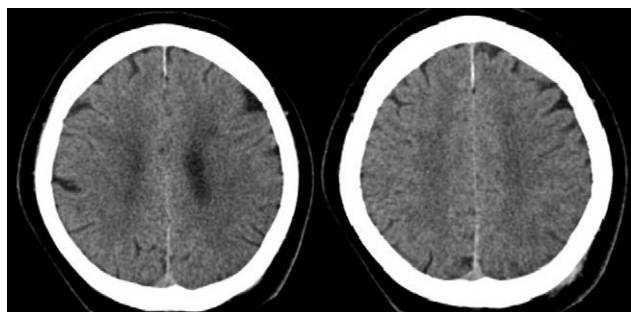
Initial computed tomography did not show any hemorrhage.
